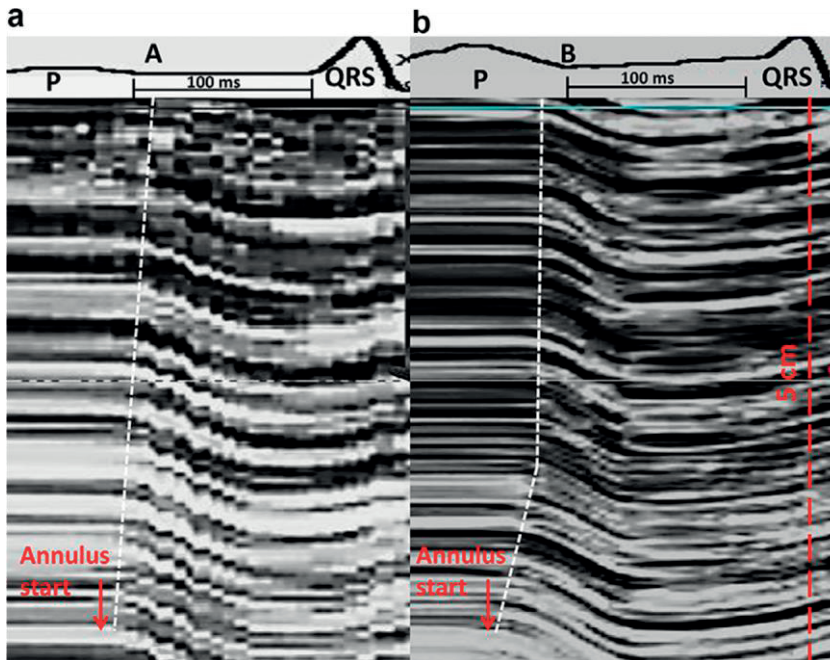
Magnified zoomed-in view of anatomic M-mode tracings along the interventricular septum, at 250 Hz, over 5 cm, just after the start of the echocardiogram P wave and before the onset of the next QRS complex. The annulus is marked with a red arrow. (a) HCM patient with a linear MSPa velocity slope. The downward tissue shift as seen propagating along the M-mode line also follows a straight line (dotted line). (b) HCM patient exhibiting non-constant velocity of the MSPa. The first tissue downward motion has an initial milder slope, followed by a very steep one along the M-mode line. HCM = hypertrophic cardiomyopathy; MSPa = myocardial stretch post-atrial contraction.
